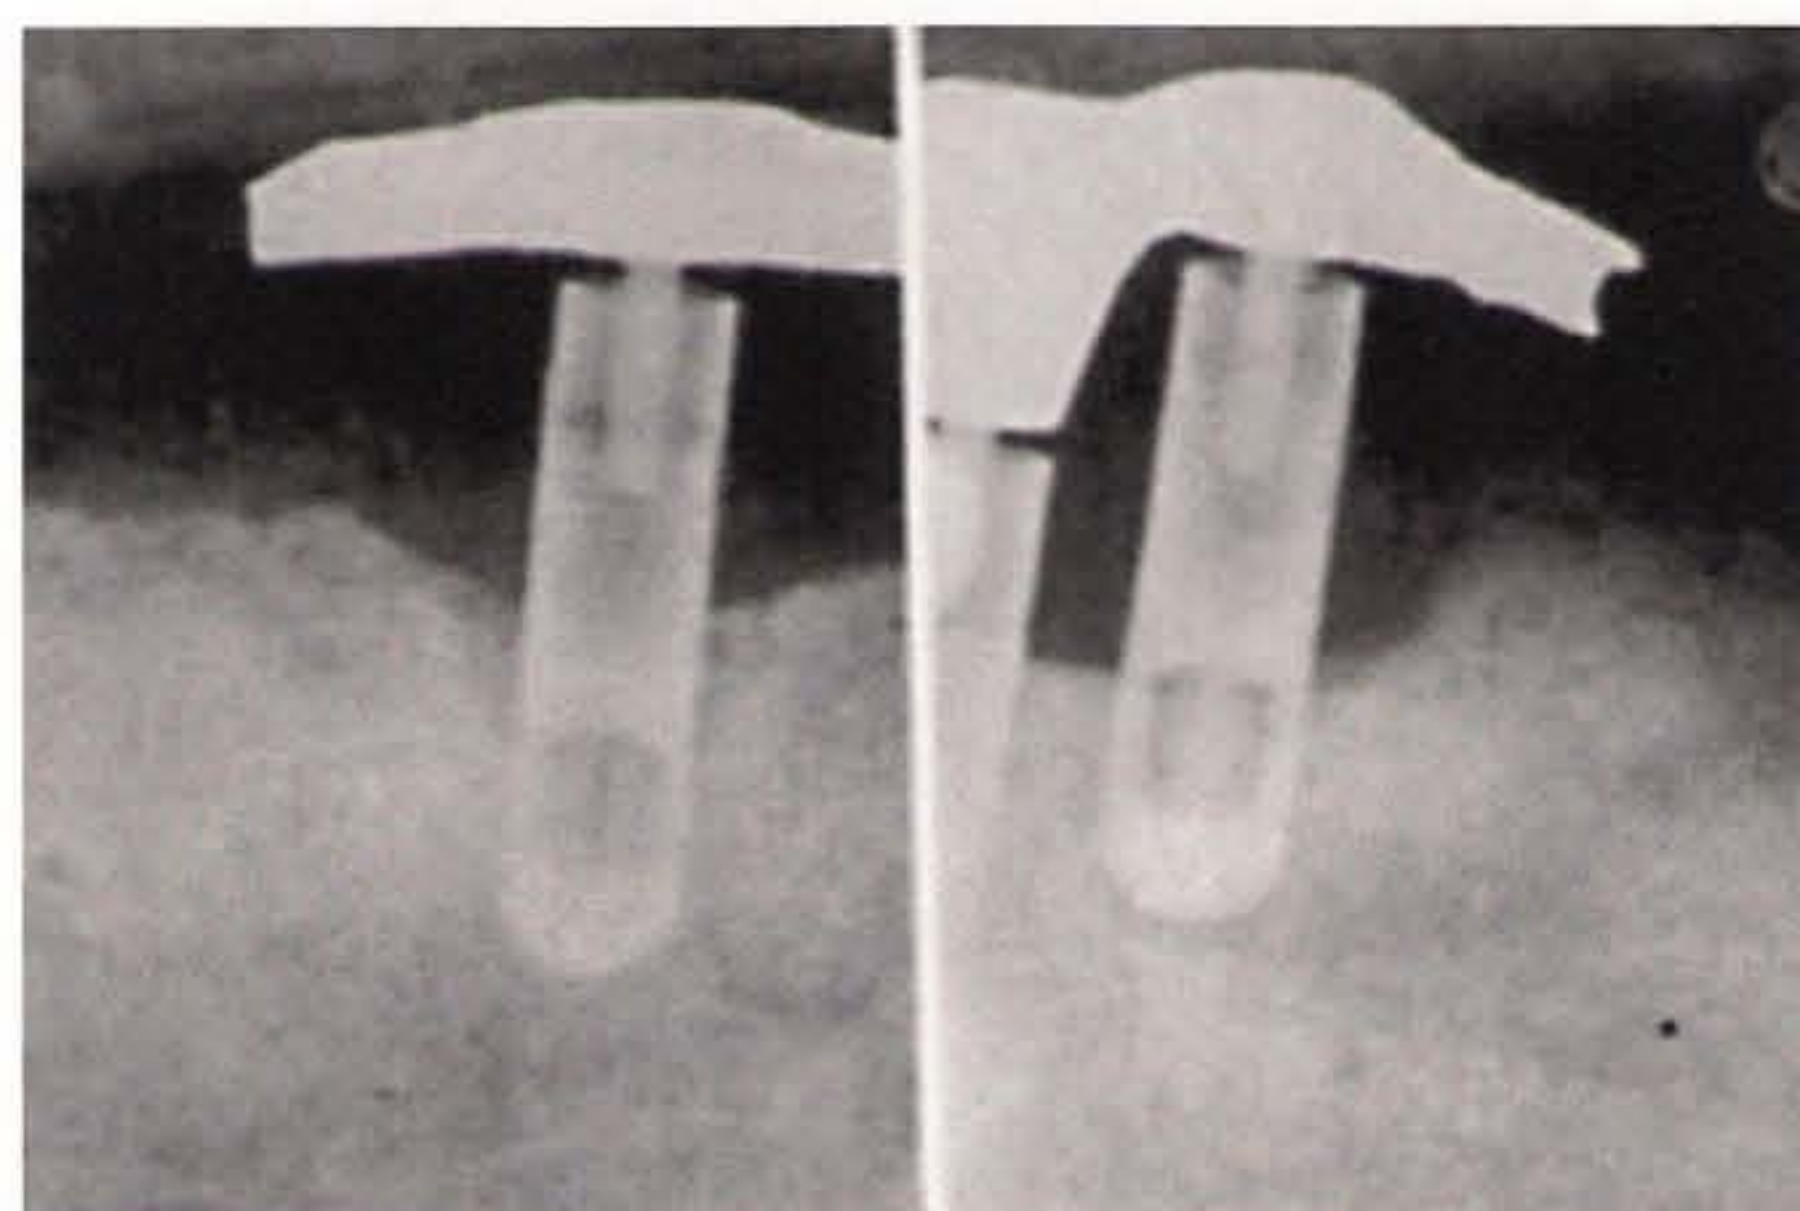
Radiographic examination of a coated implant. There is evidence of peri-implant bone loss after prosthetic loading.
